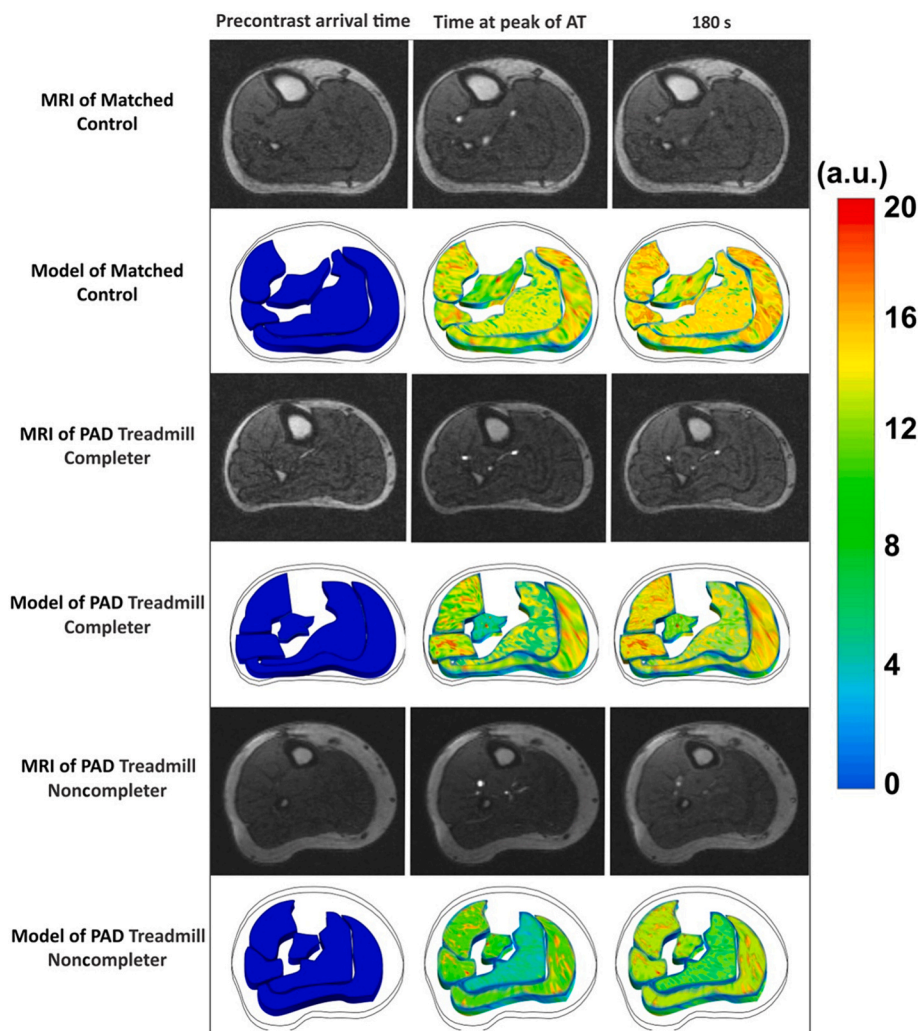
Contrast-enhanced Magnetic Resonance Imaging (MRI) Has Also Been Used in Microvascular Disease in Peripheral Artery Disease (PAD). Ginnich et al. Applied Contrast-enhanced MRI in 3 Different Types of Patients (Healthy Control, PAD Patient After a Completed 6-min Treadmill Protocol, and PAD Patients Who Were Not Able To Complete The Treadmill Protocol) and Evaluated at 3 Different Time Points (Pre-contrast Arrival Time, Time at the Peak of the Anterior Tibial Artery, and 180 Seconds After). The Images Were Analyzed Using Computational Microvascular Modeling of 5 Distinct Calf Muscle Compartments. The Model Revealed Marked Differences Across the Microvascular Response in the Different Patients, Time Points, and Muscle Compartments. *Figure from Ginnich et al. Journal of the American Heart Association. 2023;12:e027649.*
